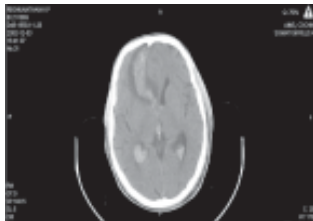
Non contrast CT Scan of the brain showing a right frontal lobe hematoma causing mild oedema and mass effect with extension of the bleed into lateral, 3rd and 4th ventricles.
